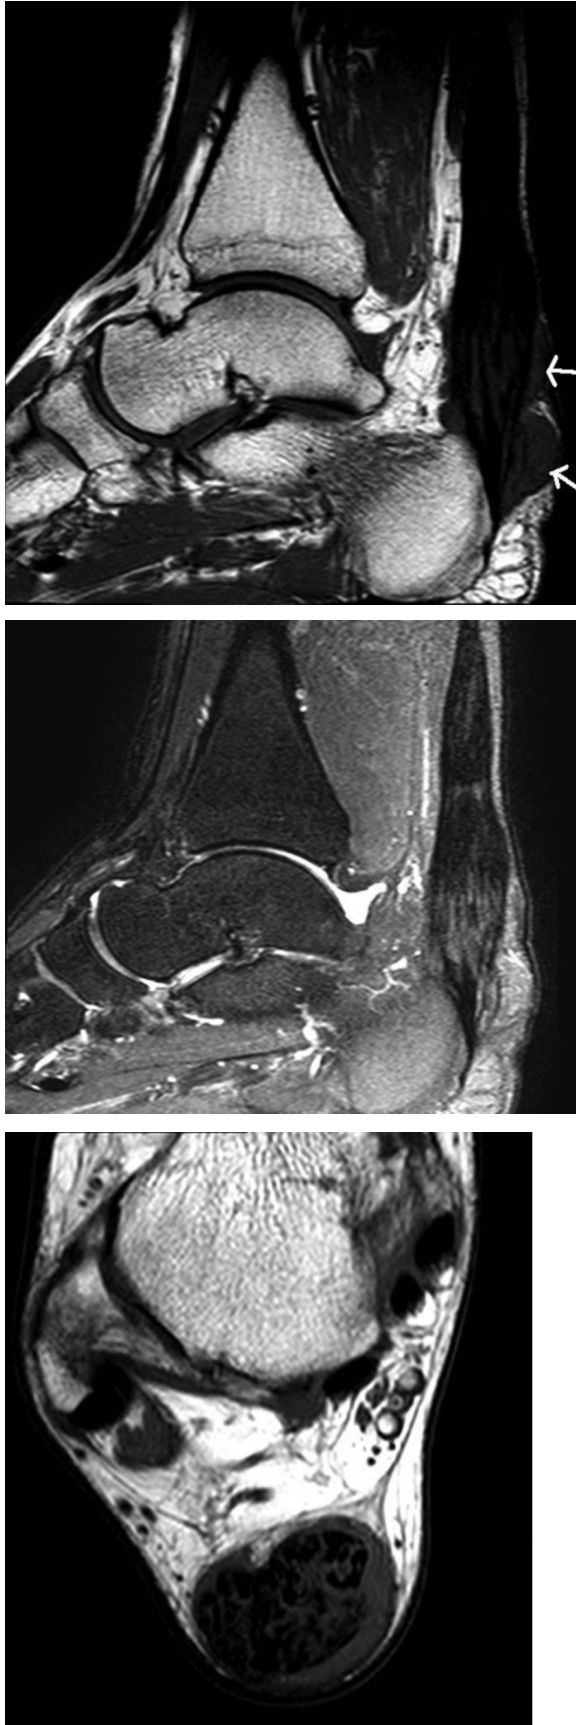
38-year-old man with multitendon xanthomatosis. Top: Sagittal T1-weighted MRI of the ankle shows that the Achilles tendon is fusiformly enlarged, with both intratendinous vertical striations and more exophytic nodular masses (arrows). These masses are well visualized, in contrast to the surrounding fatty tissues. Middle: Sagittal T2-weighted fat-suppressed MRI demonstrates fusiform Achilles-tendon enlargement, with abnormal vertical striations interdigitating within the tendon as well as nodularity and abnormal signal around the tendon. The more exophytic nodular masses noted in the top image are less conspicuous on T2-weighted, fat-suppressed images. Bottom: Axial T1-weighted MRI of the Achilles tendon shows fusiform tendon enlargement, with interdigitating vertical striations and abnormal soft tissue around the tendon, predominately dorsomedial.
